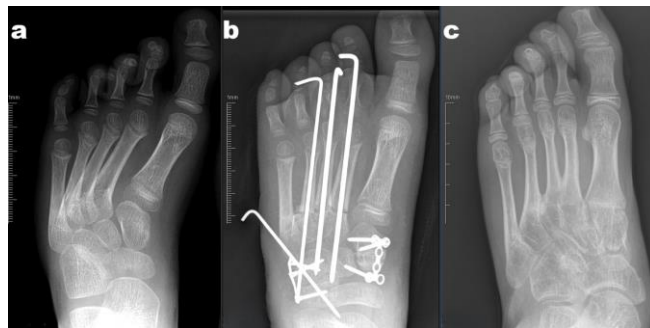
A 7-year-old patient's a) preoperative radiograph, b) postoperative radiograph, c) follow-up radiograph of the patient 6 years later.
